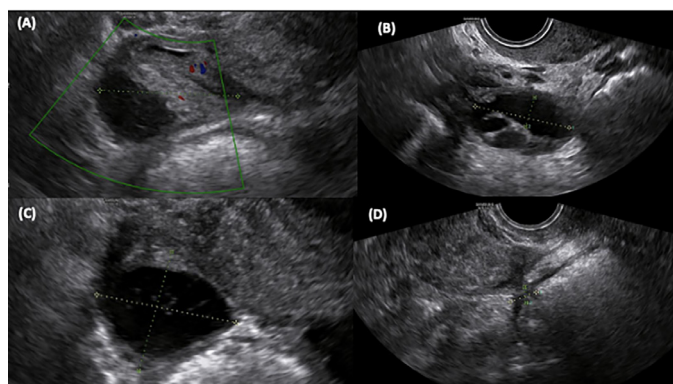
Ultrasound scan at 6 months (case 3). Residual ovarian tissue with follicular activity is observed (A-C). A nodule of deep endometriosis infiltrating the anterior wall of the rectum is visible in the posterior compartment (D).
